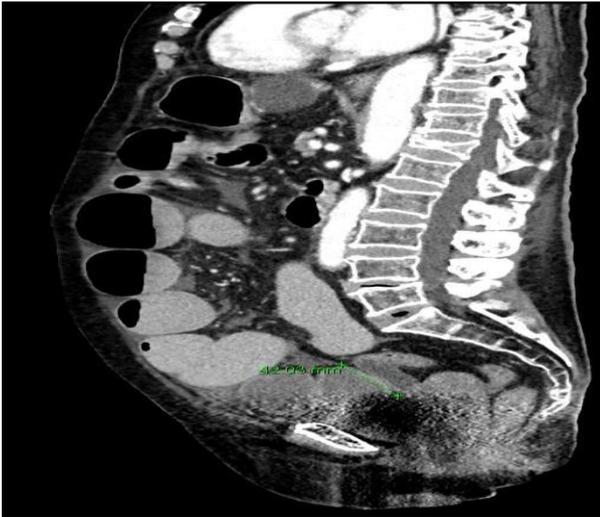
Sagittal CT demonstrating pelvic abscess collection.
